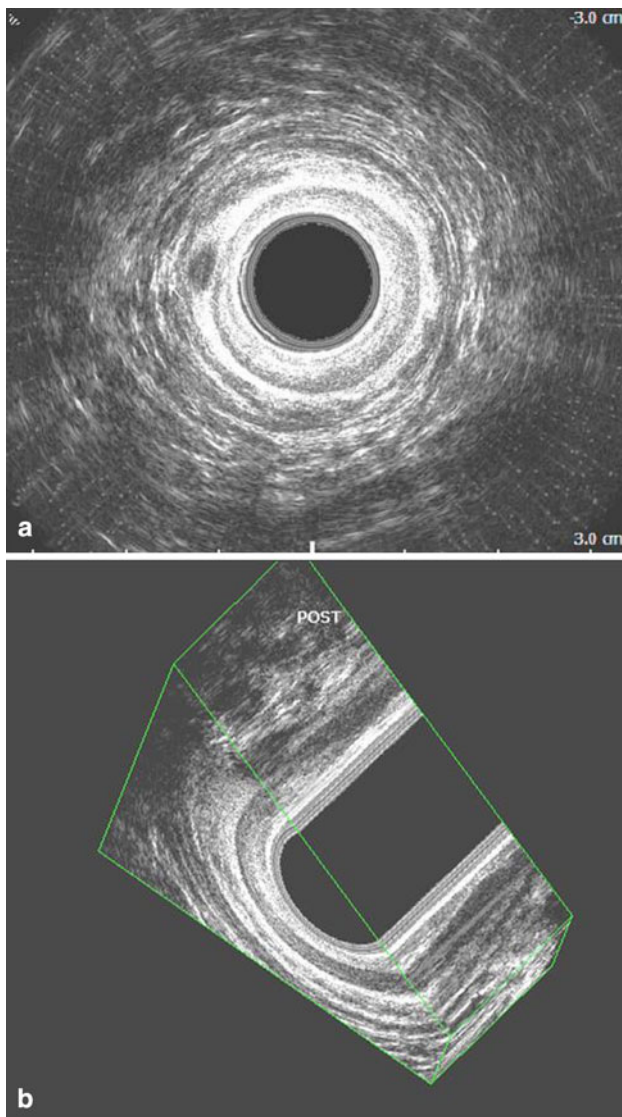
a Two-dimensional transverse endoanal ultrasound. The intersphincteric abscess is located in the posterior distal anus. Its maximal diameter is 4 mm. b 3D oblique endoanal ultrasound view of the same patient showing a small hypoechoic mass (ISS) located in the posterior intersphincteric plane. The mass is 6 mm in height and is connected to the posterior internal anal sphincter (IAS)
